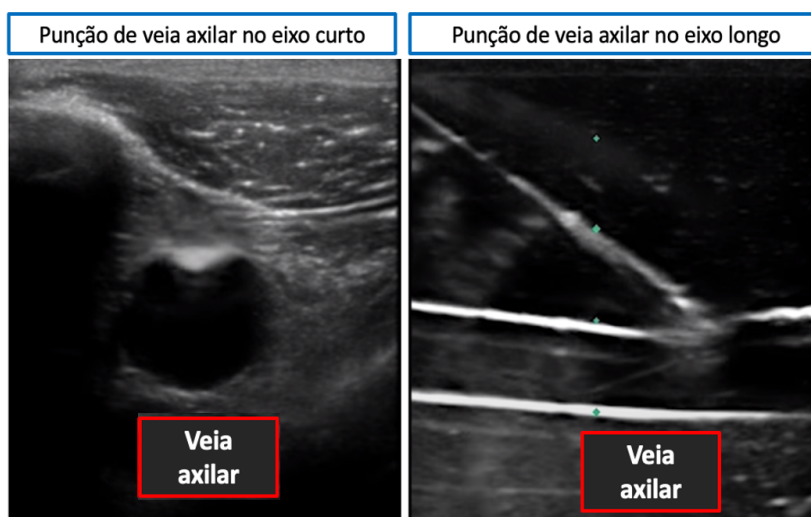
Exemplo de punção de veia axilar guiada por ultrassonografia nos eixos curto e longo.
